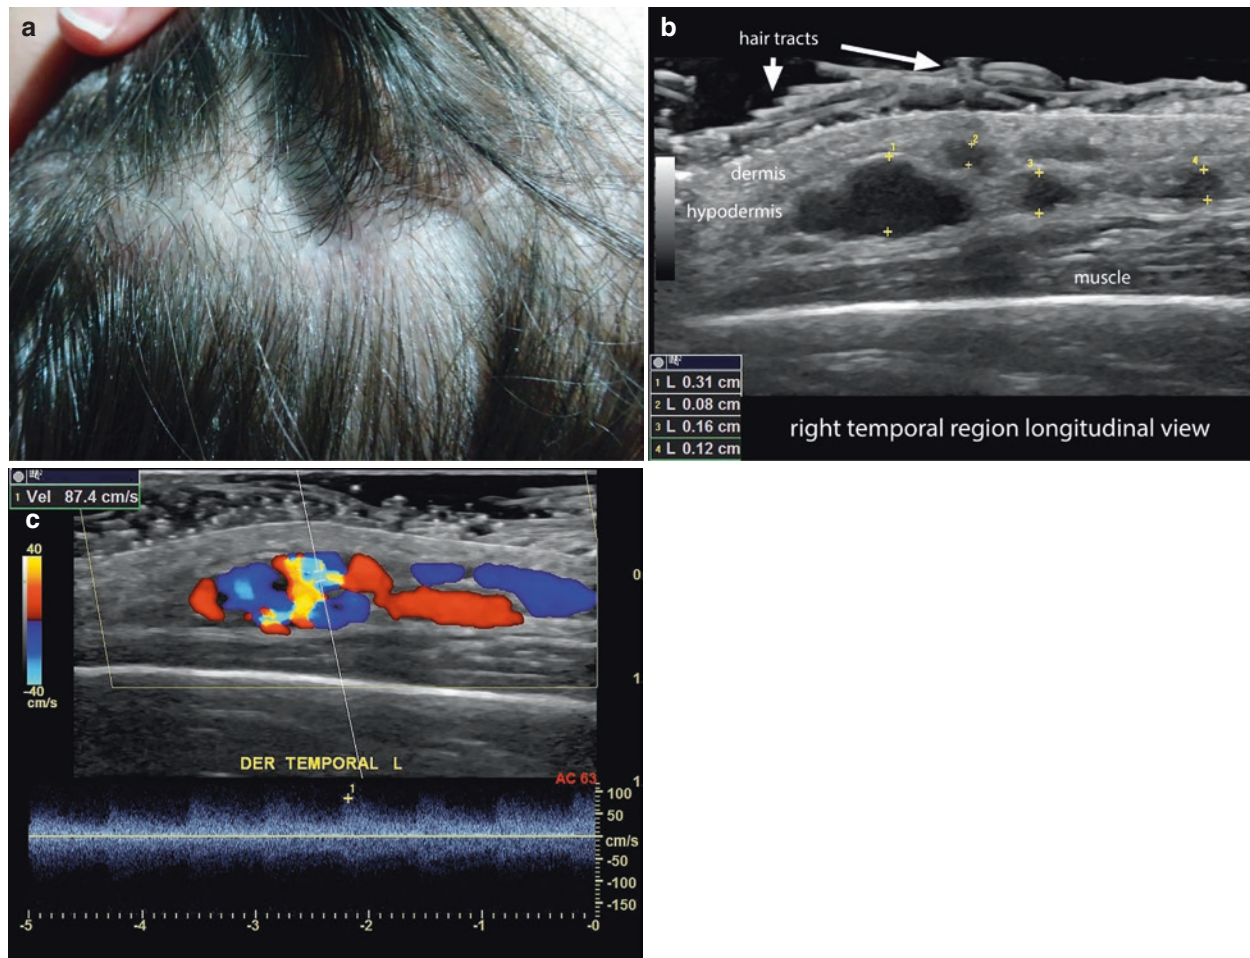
High-flow arterial vascular malformation. (a) Clinical image of the right temporal region in the scalp. (b) Greyscale ultrasound (right temporal region, longitudinal view) presents multiple anechoic, lacunar, hypodermal communicating spaces and tracts (between markers), which vary in their thickness between 0.8 and 3.1 mm. (c) Color
